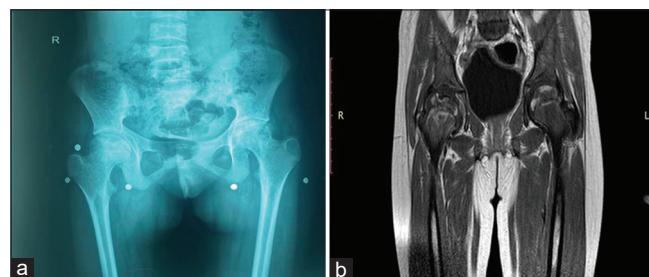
Stage 3 avascular necrosis. (a) plain radiography, (b) MRI of the hip. Both show early collapse and crescent sign (subchondral lucency)
